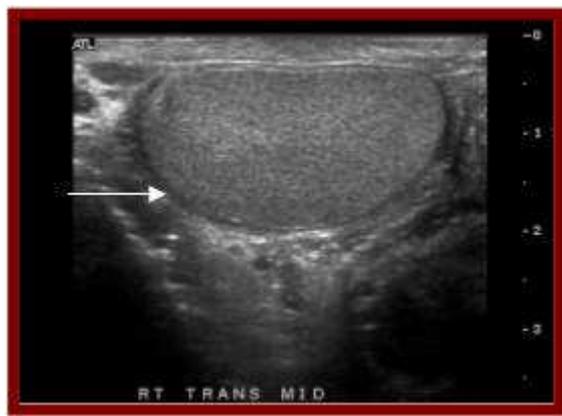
This ultrasound image through the middle portion of a testis demonstrates the homogenous appearance of the testis. Note the thin hypoechoic ring of fibrous tissue surrounding the testis giving it an encapsulated appearance. This ring is the tunica vaginalis (white arrow), which contains a small amount of fluid between its layers (visceral and parietal tunica) ⁽¹⁾.
